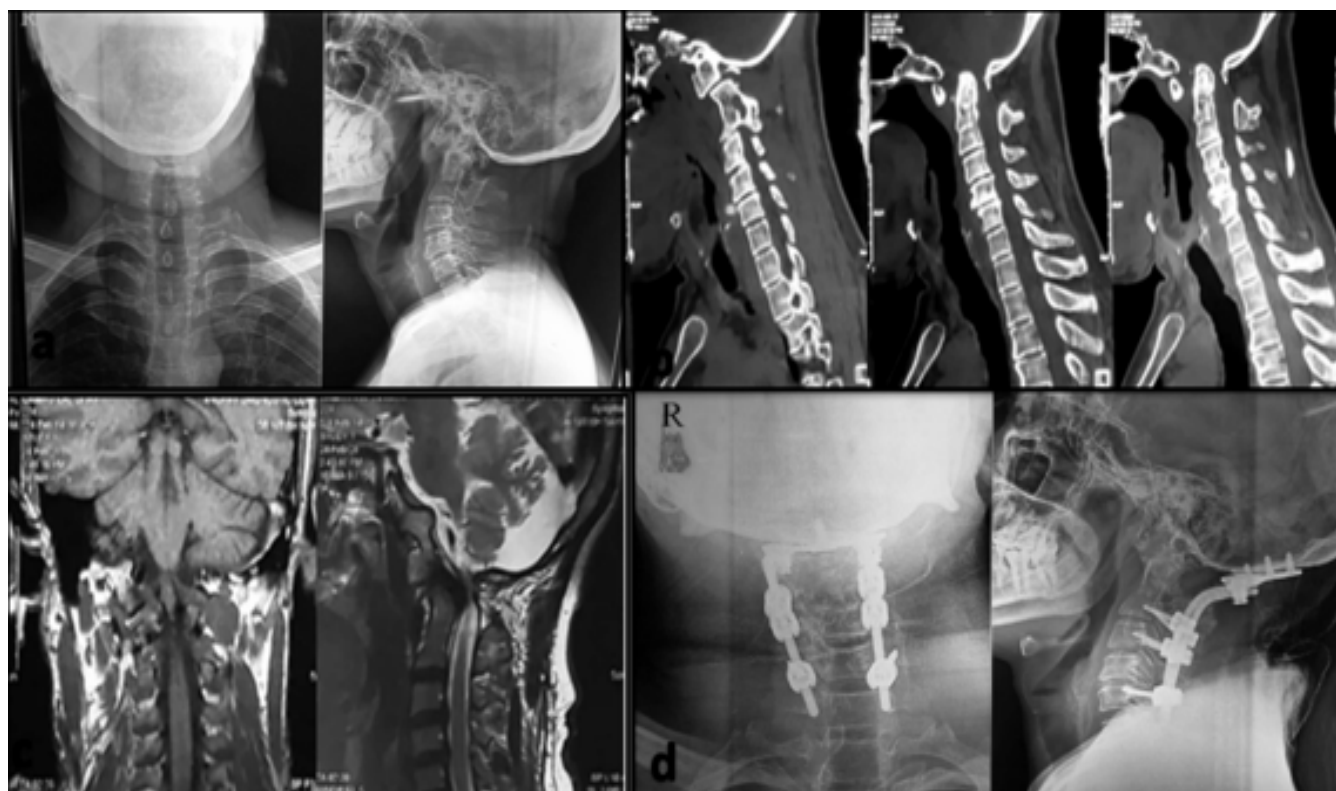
Preoperative and Postoperative Radiological Assessment of Basilar Invagination With Atlantoaxial Instability Following OccipitoCervical Fusion (a) Preoperative anteroposterior and lateral cervical radiographs demonstrating craniovertebral junction malalignment with basilar invagination and atlantoaxial instability. (b) Preoperative sagittal computed tomography (CT) images showing superior migration of the odontoid process, atlantoaxial subluxation, reduction in the clivo-axial angle, and significant craniovertebral junction deformity. (c) Preoperative magnetic resonance imaging (MRI) demonstrating marked cervicomedullary compression with ventral brainstem indentation secondary to basilar invagination and C1-C2 instability. (d) Postoperative anteroposterior and lateral radiographs demonstrating satisfactory occipito-cervical fixation extending from the occiput to C5 with screw-rod construct, restoration of craniovertebral alignment, and adequate stabilization following foramen magnum decompression and C1 posterior arch excision.
